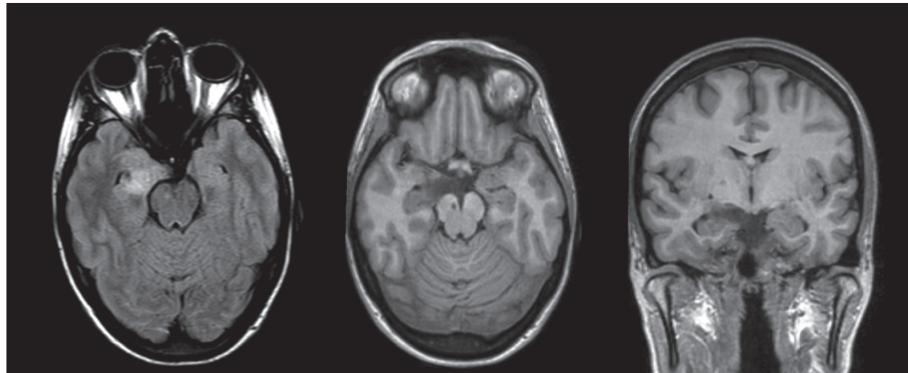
MRI showing a right medial temporal lesion, with involvement of the uncus, amygdala and head of the hippocampus, with ill-defined limits. The lesion is not enhanced after gadolinium contrast injection. These findings are compatible with a dysembryoplastic neuroepithelial tumour.
